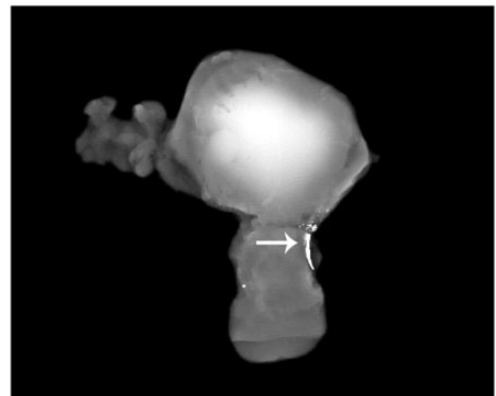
Retained needle on X-ray examination using low-energy X-rays in the right lateral part of the cervix just below the uterine corpus.
